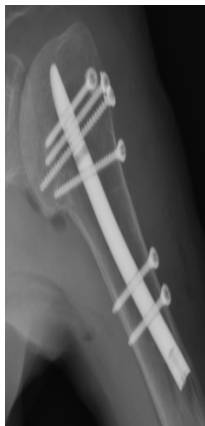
Postoperative radiography on AP view.
